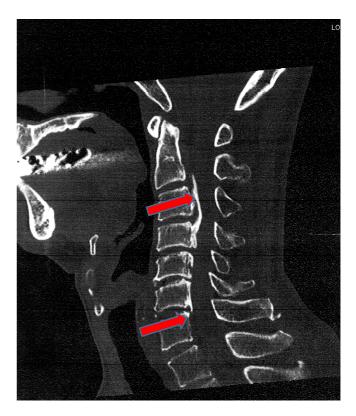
Case 1, CT image: Vertical progression of ossification 39 months after first visit
